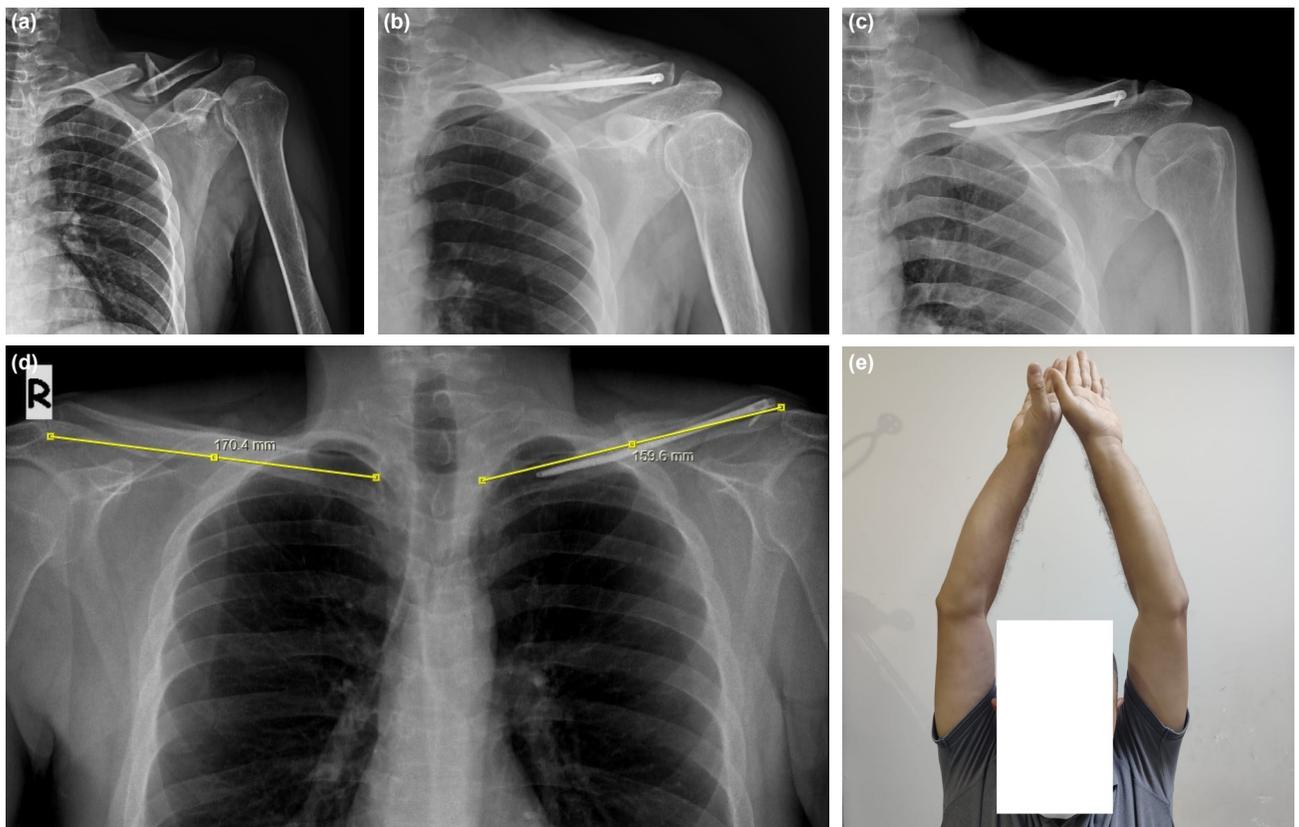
(a, b) Pre-operative and post-operative 8 week anteroposterior X-rays of a 38 year-old male, who sustained a comminuted fracture of the left clavicle, (c, d) 2 year post-operative anteroposterior X-ray after union with post-traumatic shortening of 6.3%, and (e) clinical image of same patient.
